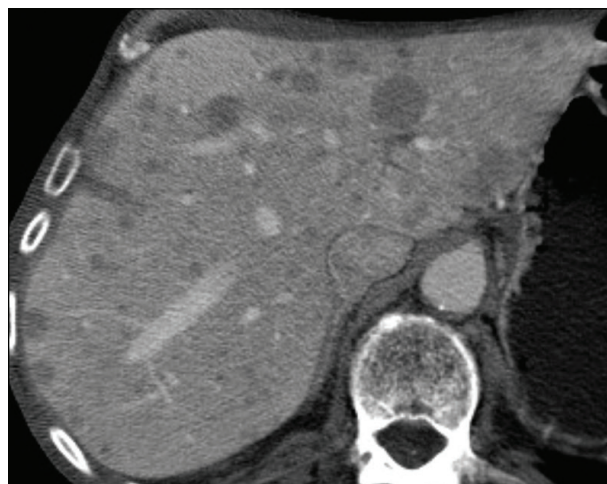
Contrast-enhanced CT obtained prior to radioembolization demonstrated multiple bilobar liver lesions.
